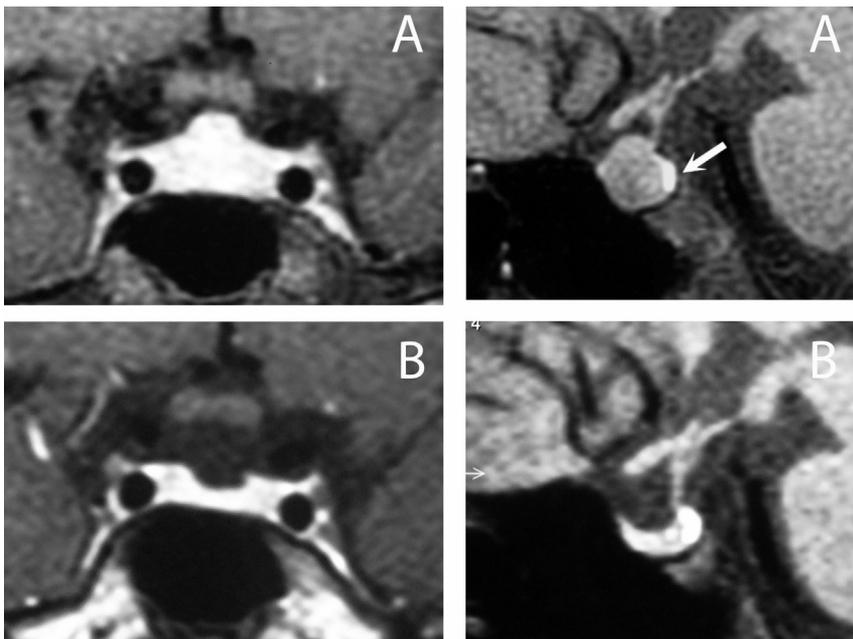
Magnetic resonance findings in a case of pituitary hyperplasia due to primary hypothyroidism. The patient was an 8 years-old girl who presented with headache. Initial radiological diagnosis was “pituitary macroadenoma”. Panels A (at baseline): coronal T1-weighted postcontrast (left) and sagittal (right) images show a symmetrical pituitary enlargement with a central superior convexity, homogenous contrast enhancement and the presence of neurohypophysis signal (arrow); Panels B (after 6 months of therapy with levothyroxine): coronal (left) and sagittal (right) images without abnormalities.
